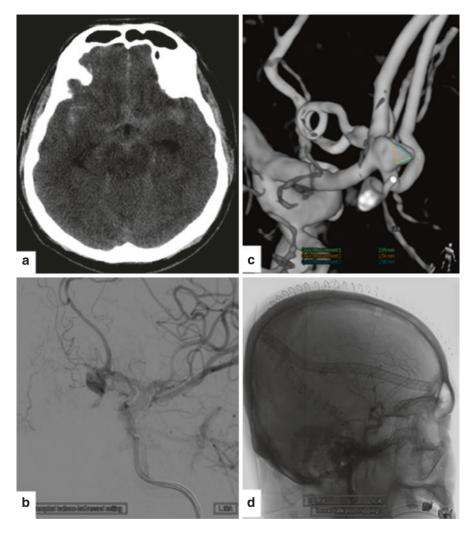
A 55-year-old Korean gentleman presented with sudden onset headache and diffuse subarachnoid hemorrhage from a ruptured anterior communicating artery aneurysm. (a) Initial head CT showing diffuse subarachnoid hemorrhage. (b) Cerebral angiogram demonstrated ruptured anterior communicating artery aneurysm. Intraprocedural rupture occurred during attempted coil embolization requiring emergent transfer to the OR for microsurgical clipping. (c) 12-month follow-up angiogram showing enlarged triangular remnant requiring (d) repeat microsurgical clipping resulting in aneurysm obliteration
